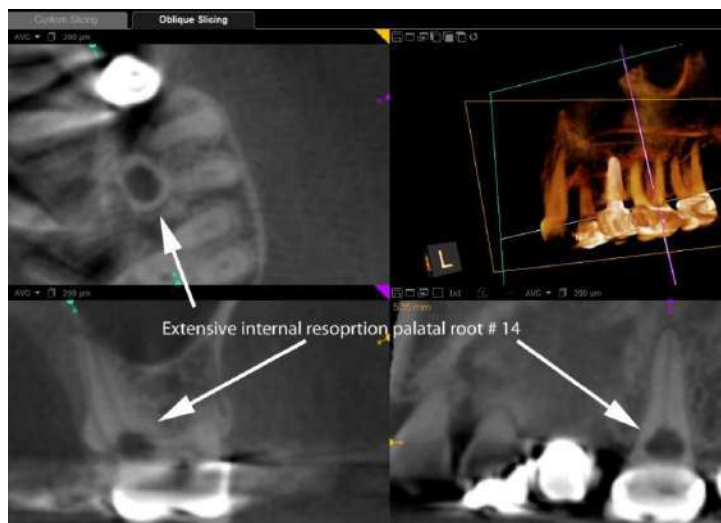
4. CBCT showing Internal root resorption
